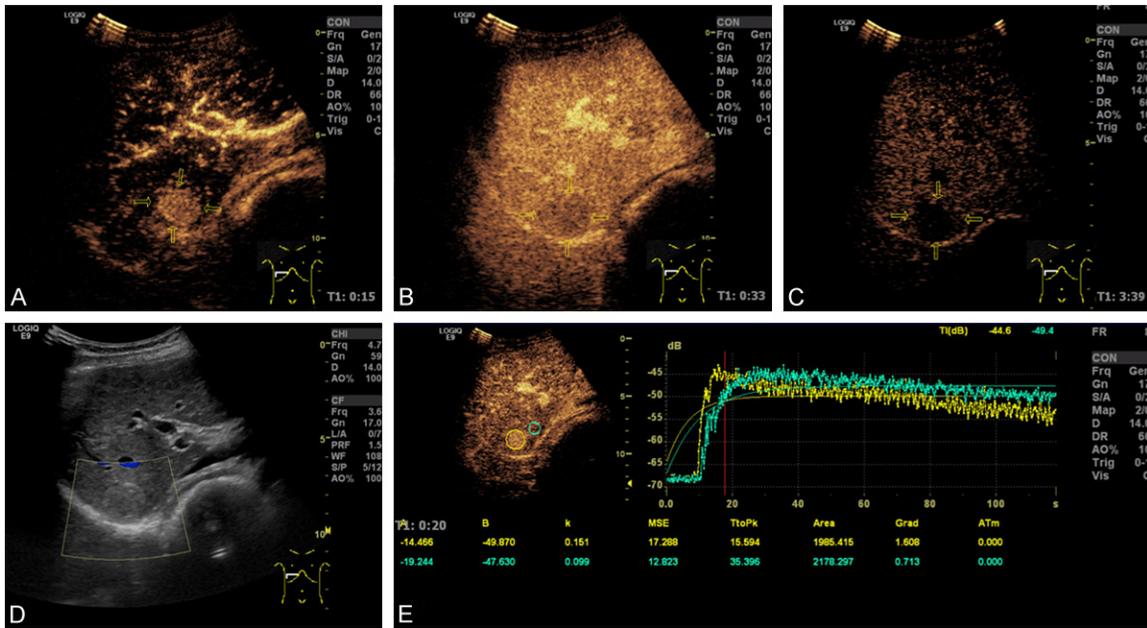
CEUS and TIC analysis for SHCC. A: CEUS image shows high enhancement on 15 s in the arterial phase; B: CEUS image shows low enhancement on 33 s in the portal phase; C: CEUS image shows low enhancement on 219 s in the late phase; D: Gray-scale ultrasound shows a hyperechoic mass within the right lobe of the liver; E: SHCC time-intensity curve is “high and sharp”.
